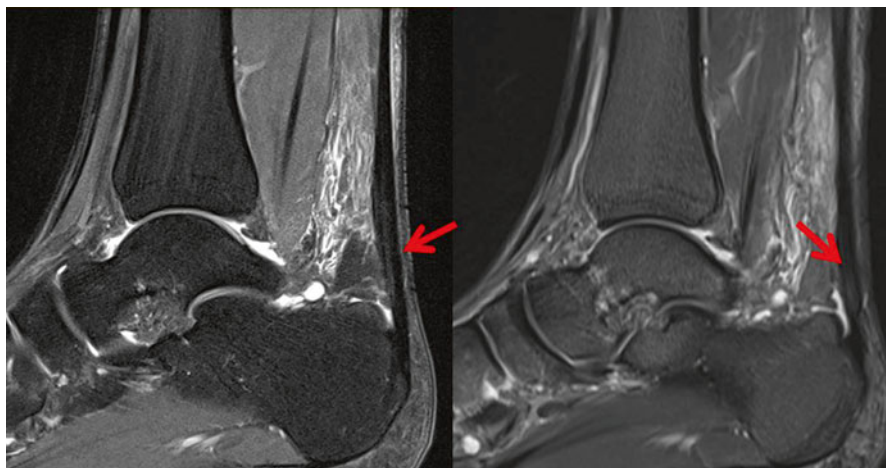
MRI imaging of Achilles tendinopathy (*arrow*)
